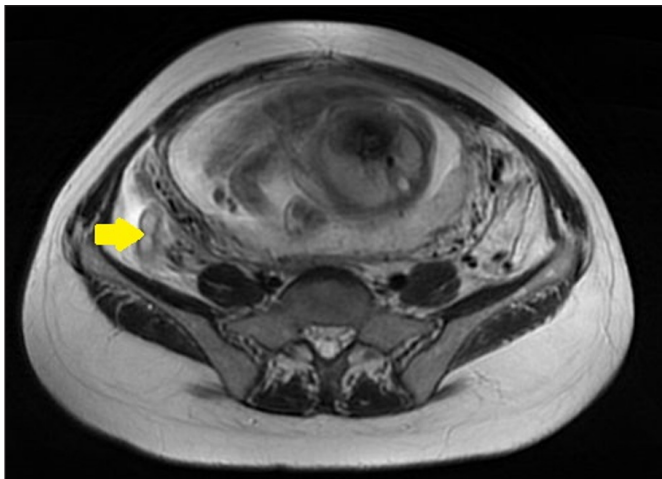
MRI Imaging Including Axial T2A Lower Abdominal Sections.
